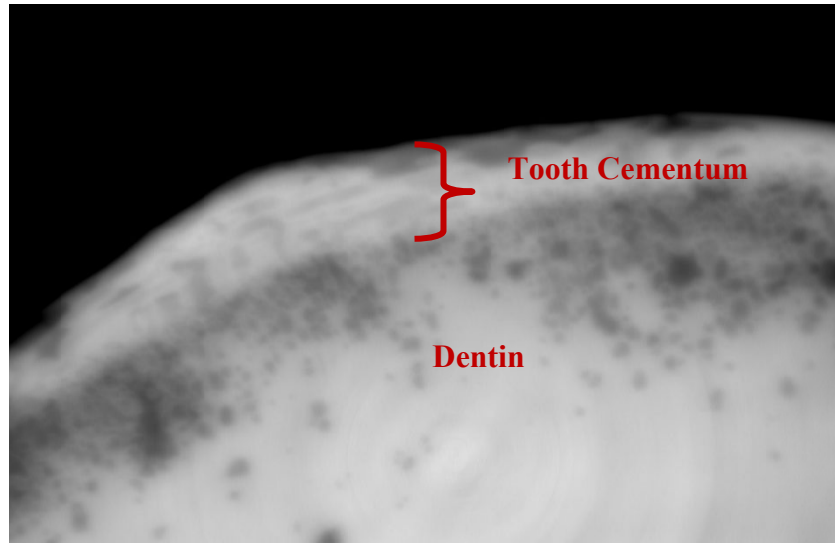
A propagation-based phase contrast SR $\mu$ CT overview scan showing the tooth cementum with a pixel length of 0.66  $\mu\text{m}$ , with cementum in the outer part indicated by the curly bracket distinguished from the subjacent dentin.
